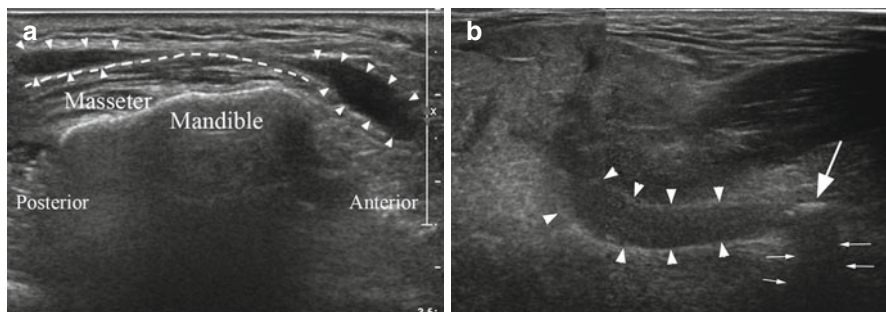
Ultrasonography of obstructive salivary gland disease. (a) shows a right submandibular gland (outlined with *dashes*) with two merged ultrasound images demonstrating the gland and also the dilated duct (outlined with *arrowheads*). Note the dilated duct extending proximally back to the hilum from a calculus located in the mid-third of the main duct (*large arrow*). The stone is calcified and has produced a post-acoustic shadow extending away from the ultrasound source (marked by the small *white arrows*). (b) demonstrates a right parotid gland duct with strictures present in the mid-third of the main duct, as it passes over the masseter muscle. The dilated duct is outlined with *arrowheads*
